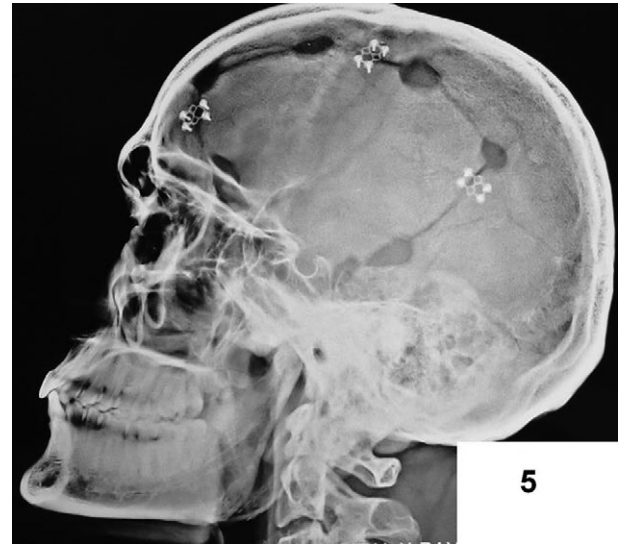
Post cranioplasty X-ray showing bone flap at proper place.
